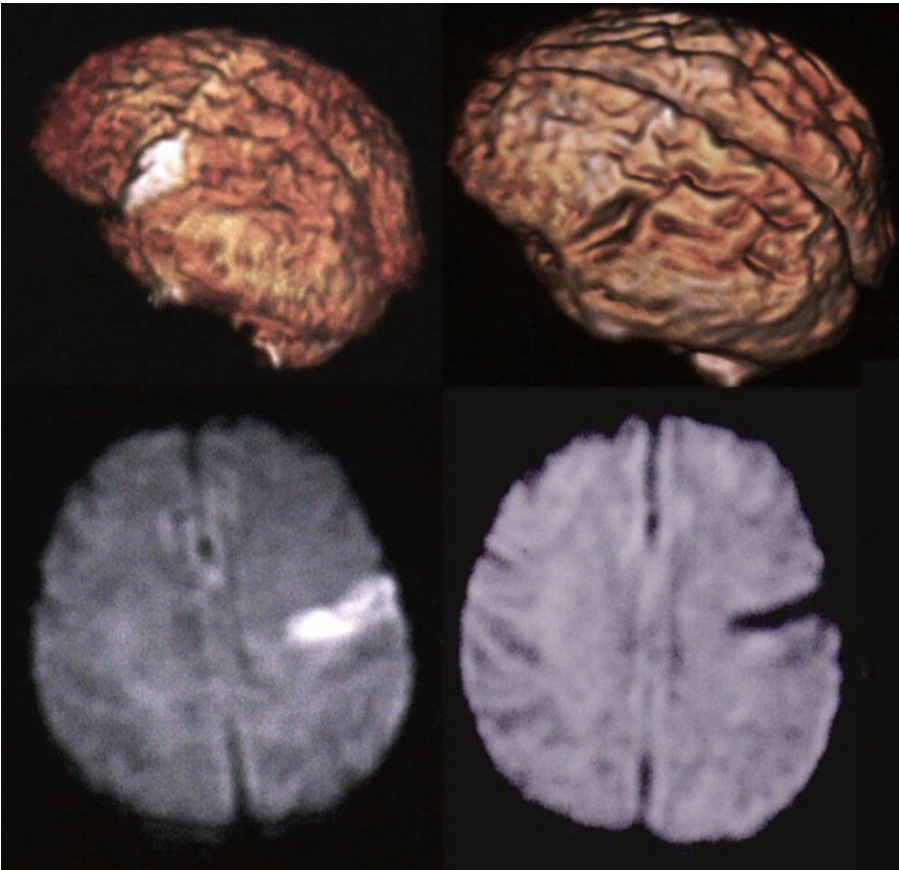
Case example showing typical classic representation of speech within the left hemisphere: *left hand panel* shows acute disruption of speech as a bright DWI positive peri-sylvian area of cortical ischemia (*right hand panel* shows this as cortical defect with focal encephalomalacia at follow-up when some speech alteration still persisted)
